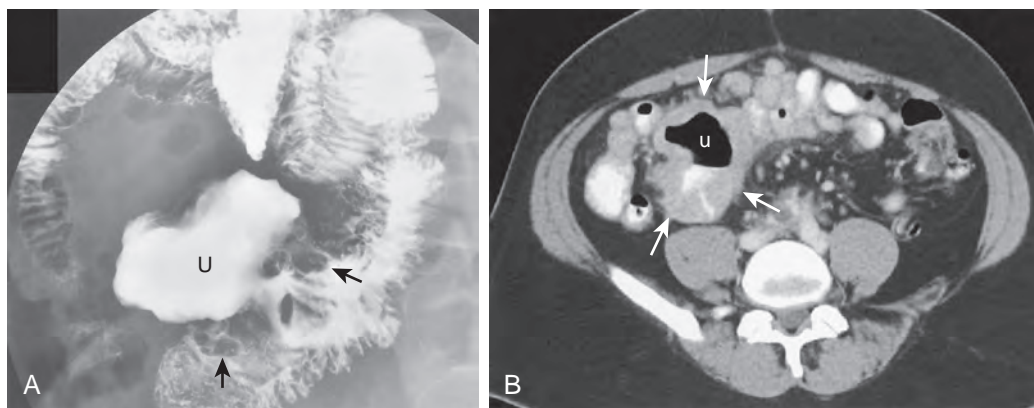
Gastrointestinal stromal tumor demonstrated on small bowel follow-through. A. Spot image shows a large, irregular, barium-filled cavity (U) on the mesenteric border of the mid-small bowel. Coarse, lobulated tumor nodules (arrows) are present adjacent to the cavity. B. Axial CT scan shows the bulk of the tumor (arrows) surrounding the cavity (u). The mucosal changes are not apparent. This patient presented with GI bleeding.
